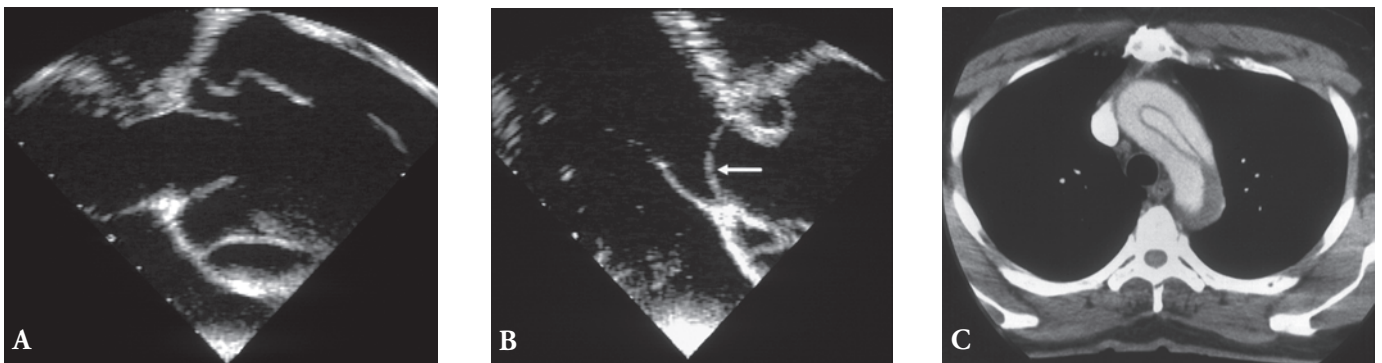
A*, Multiplane transesophageal echocardiogram (longitudinal view) shows an intimal flap in the ascending aorta. *B*, In diastole, the intimal flap prolapses through the aortic valve (*arrow*). *C*, Computed tomogram (contrast-enhanced) shows a spiraling intimal flap in the transverse aortic arch.
